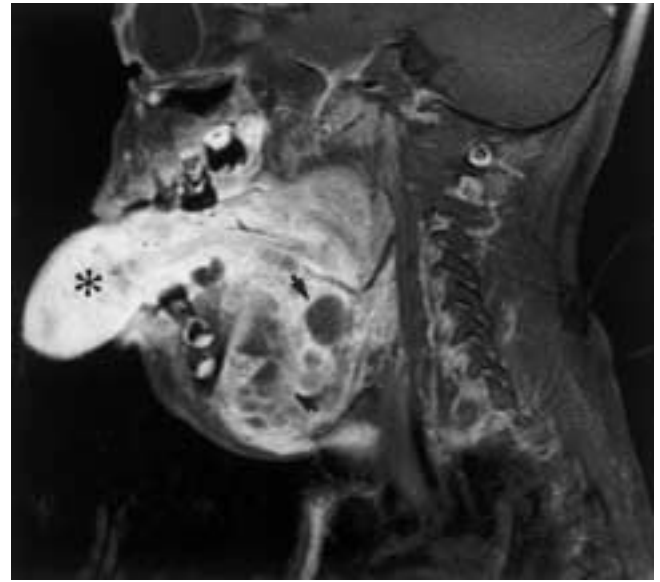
Macroglossia and complex mixed vascular malformation of the tongue, floor of the mouth, and neck. The patient presented with a mass and respiratory obstruction, for which tracheostomy was required. The malformation was complicated by multiple episodes of hemorrhage and ulceration. Contrast-enhanced, fat-suppressed sagittal T1-weighted image shows macroglossia with intense enhancement of the tongue (asterisk) and a macrocystic lymphatic malformation in the floor of the mouth (arrows). The patient was treated with a combination of embolization of the tongue and ethanol sclerotherapy to the tongue and floor of the mouth. There was subsequent resolution of hemorrhage and significant reduction in the size of the tongue.
